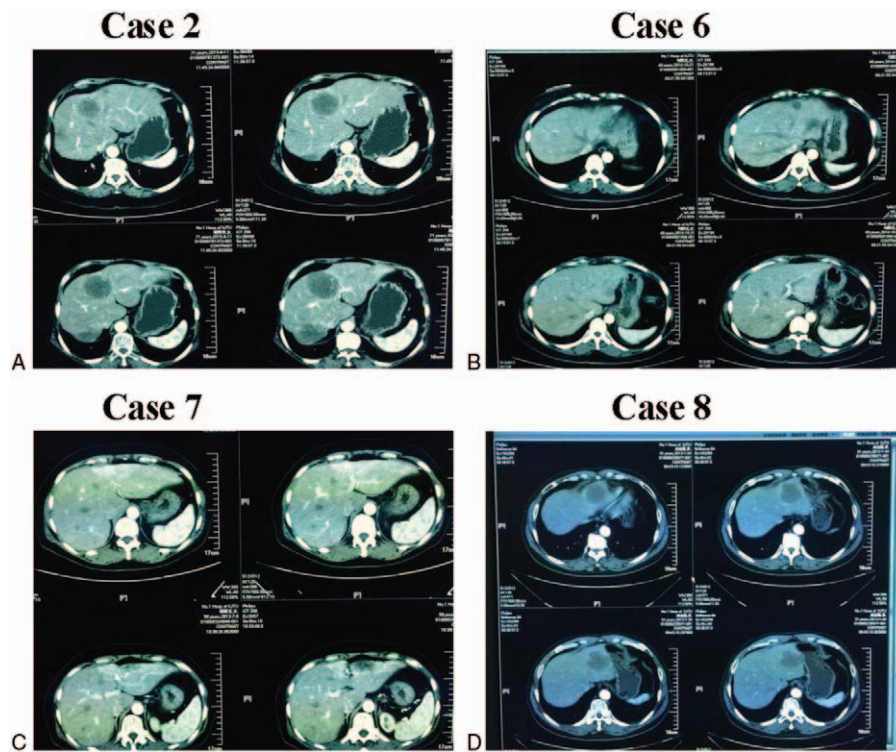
Abdominal computed tomography (CT). (A) Circular enhancements (case 2); (B) multiple nodular lesions (case 6); (C) peripheral enhancements (case 7); and (D) no obvious enhancements (case 8).
